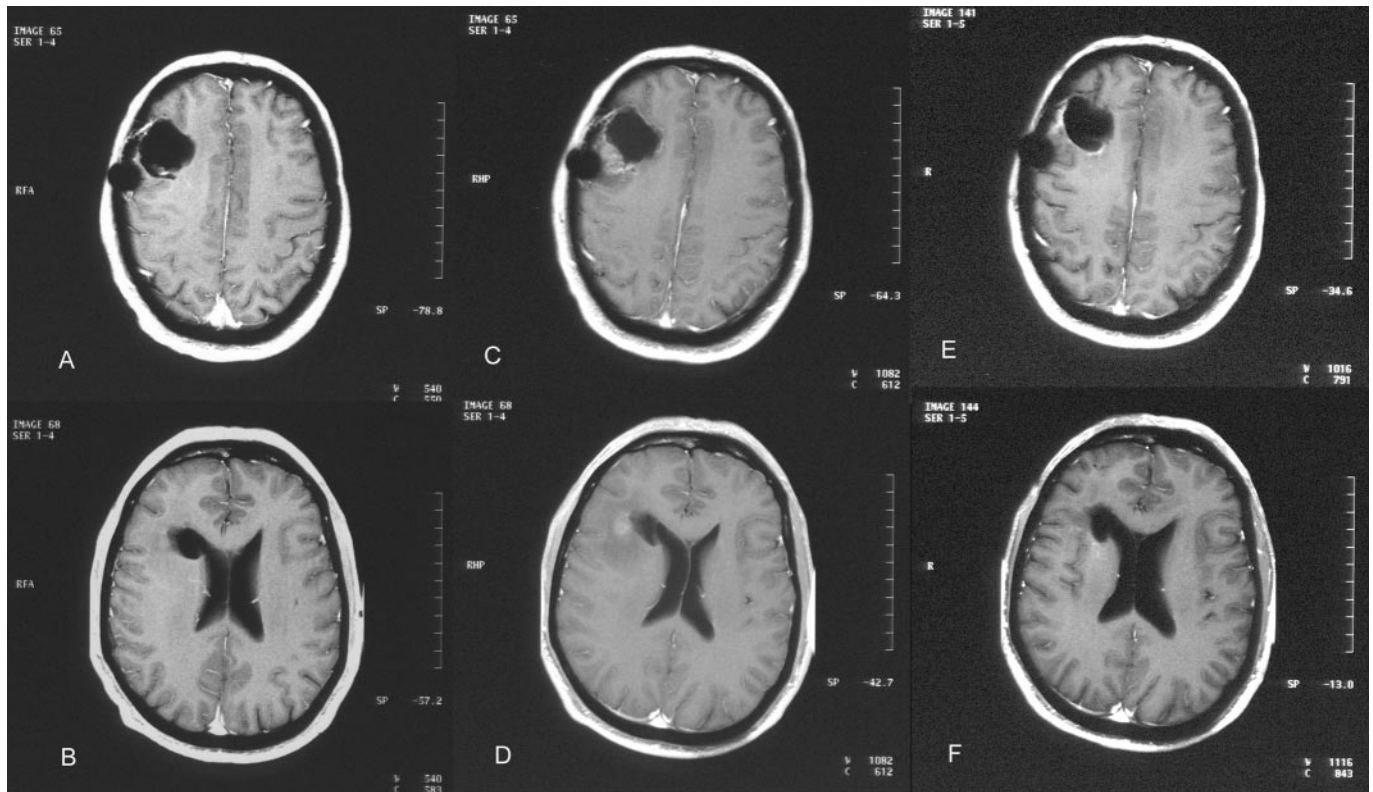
(A through F) Index case: T1-weighted images after gadolinium administration. (A, B) Immediately following the end of radiotherapy showing the post-resection cavity; (C, D) 2 months after radiation therapy at the time of clinical signs and symptoms showing a new area of gadolinium uptake and edema causing a slight midline shift; (E, F) 1 year after the end of radiotherapy: resolution of edema and enhancement.
